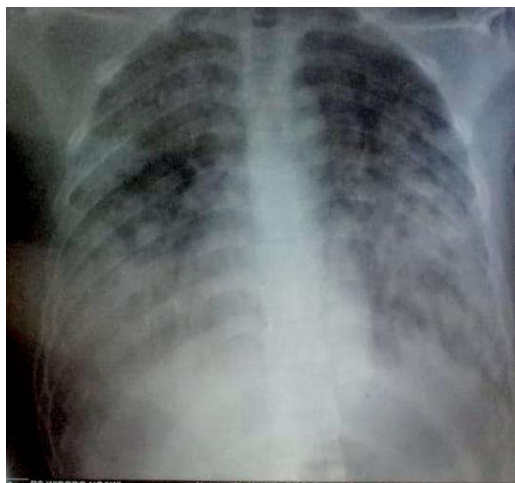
First day chest X-ray
